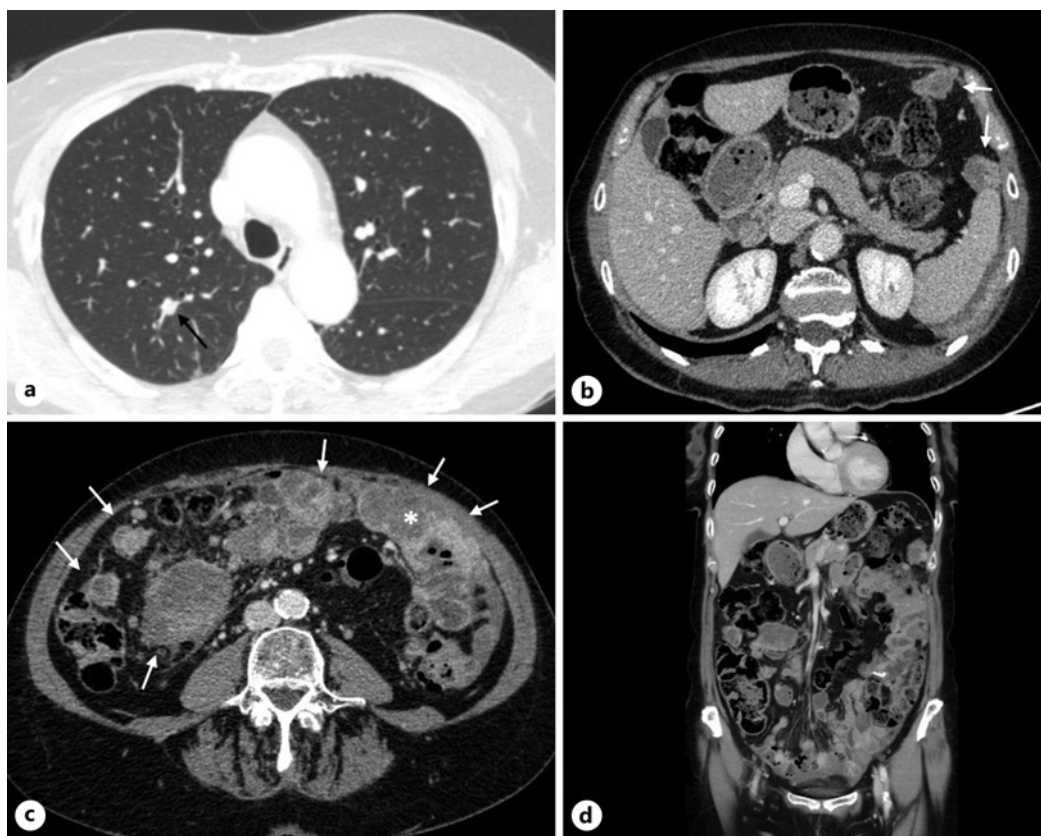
Baseline evaluation after target therapy. Volumetric CT MPR images in the axial (a–c) and coronal (d) planes after intravenous contrast media administration. a There is a metastasis (black arrow) in the posterior segment of the upper lobe of the right lung. Multiple metastatic implants on the peritoneal surface (white arrows) ranging in size from a few millimeters to masses (b, c). The omentum, located anteriorly and to the left of the midline, appears stranded and bulky from confluent nodules (asterisk). Coronal image (d) shows confluent metastatic sites at the level of the omentum (left abdominal quadrants) and a small amount of peritoneal effusion in the pelvis.
